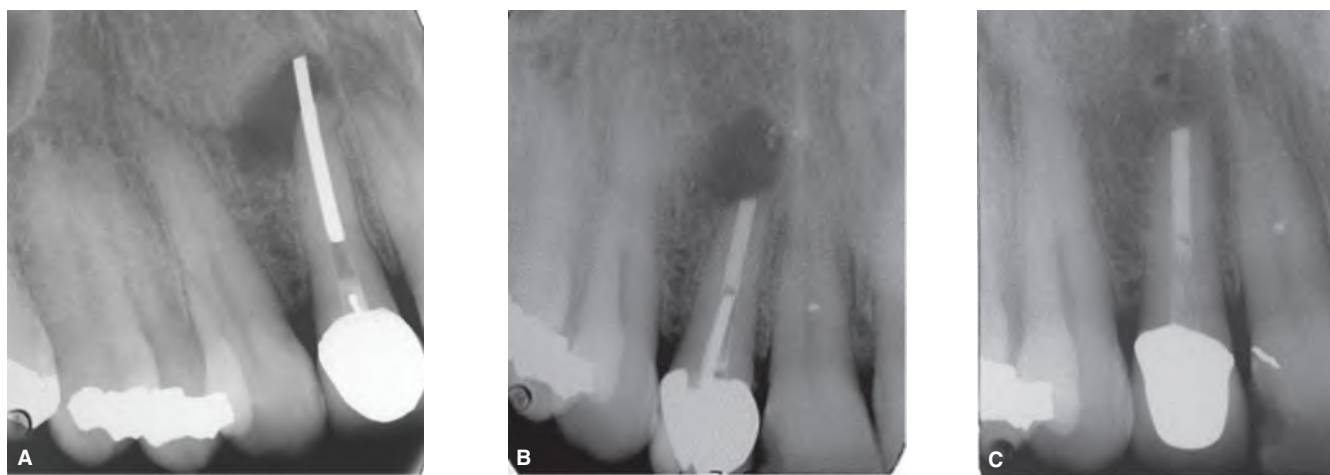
A. Periapical radiograph shows extensive radiolucency around the apex of the maxillary right incisor with an over-extended silver point and an inadequate coronal seal. B. The root canal treatment was retreated nonsurgically and surgically using MTA as root canal filling material. C. Radiograph taken three years later shows complete resolution of the periapical lesion. (Courtesy of Dr. Christopher Sechrist, Redlands, California, U.S.A.)
